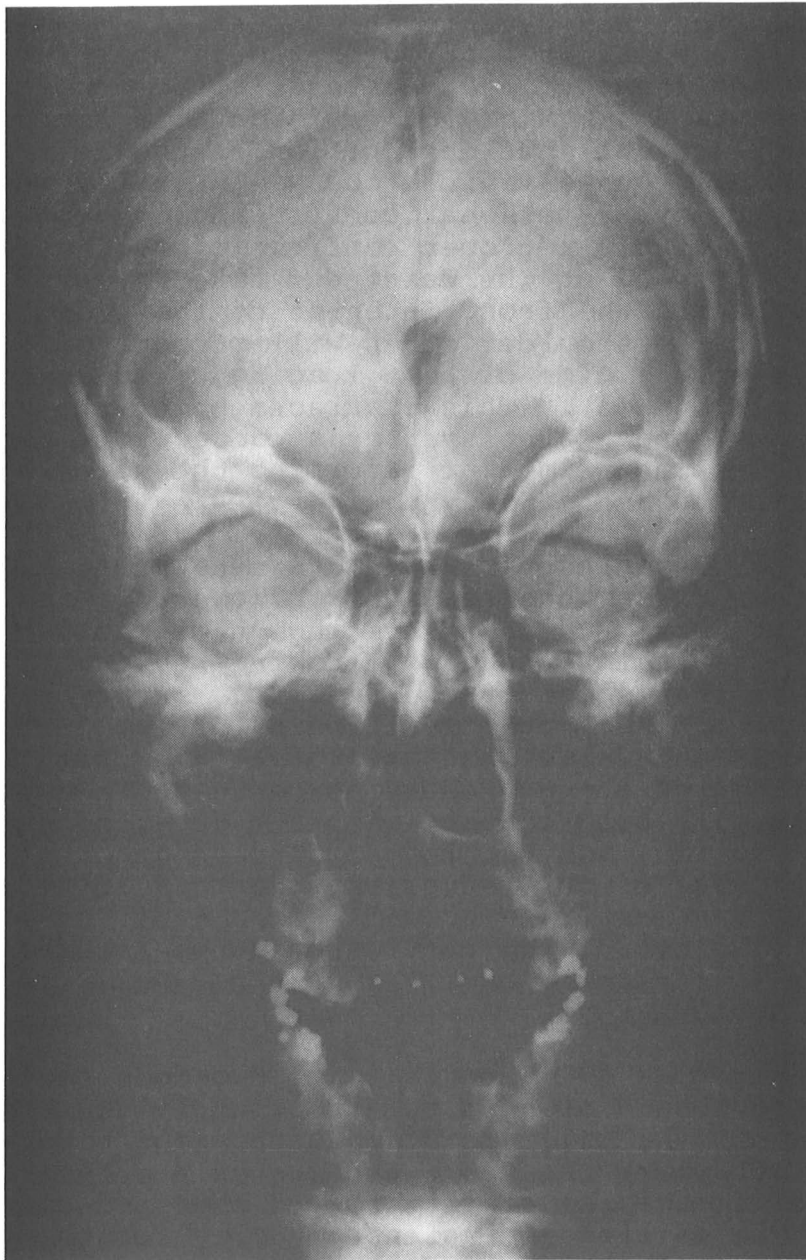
Radiograph showing frontal view of the bilateral basal and bi-occipital skull fracture to the driver in Case Study No. 2
